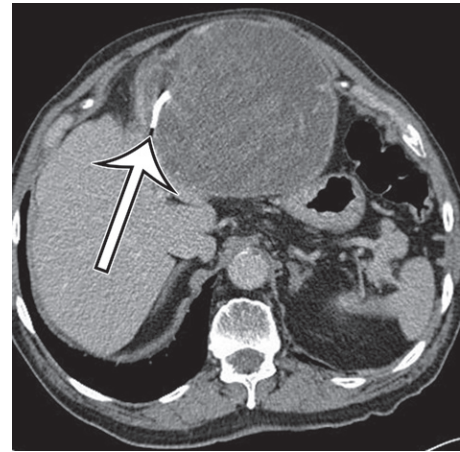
Foreign body in a 78-year-old man with epigastric pain. Axial contrast-enhanced CT image shows a thick-walled complex cystic structure in the epigastric anterior abdomen that contains a high-attenuation radiopaque marker (arrow), indicative of a retained surgical sponge.
